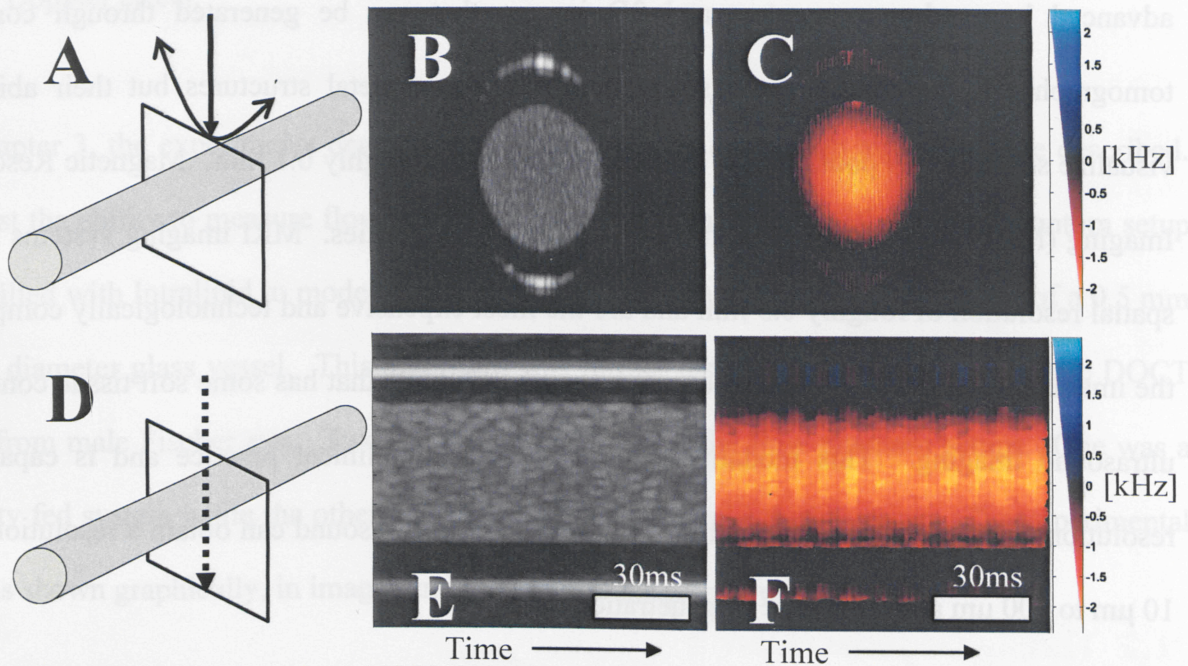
Example of B-Mode and M-Mode images. A) The sweeping motion of the probe to acquire the scan is shown while B) and C) are structural and Doppler B-Mode images from the scan. B-Mode image is a 1.5 mm x 1.5 mm square. D) The static recording of an M-Mode image through the centre of the tube. E) and F) show structural and Doppler M-Mode images. M-Mode images have a depth of 1.5 mm and span 1/8th of a second. Vessel contains 1% Intralipid fluid moving at 1.5 mm/s peak velocity.
